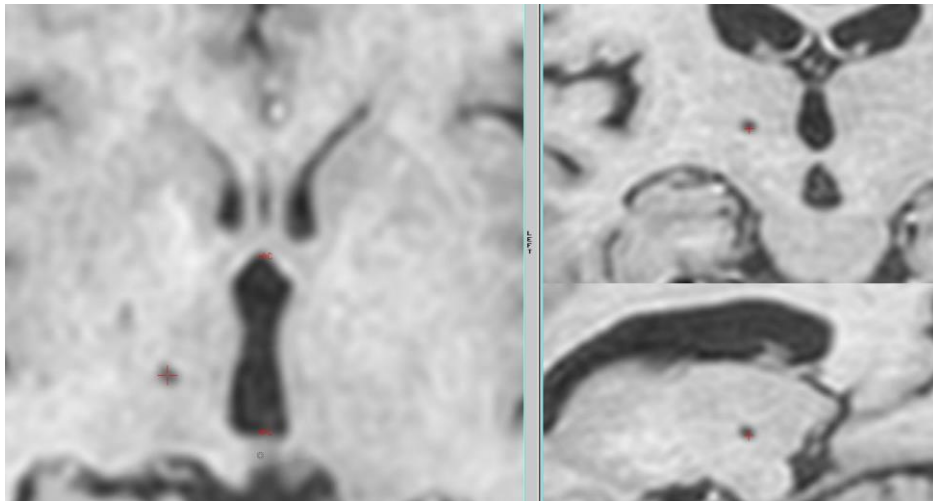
Postoperative MRI T1: Hypointense right vim lesioning (red cross). a. axial at zero level, b. coronal and c. sagittal plane
